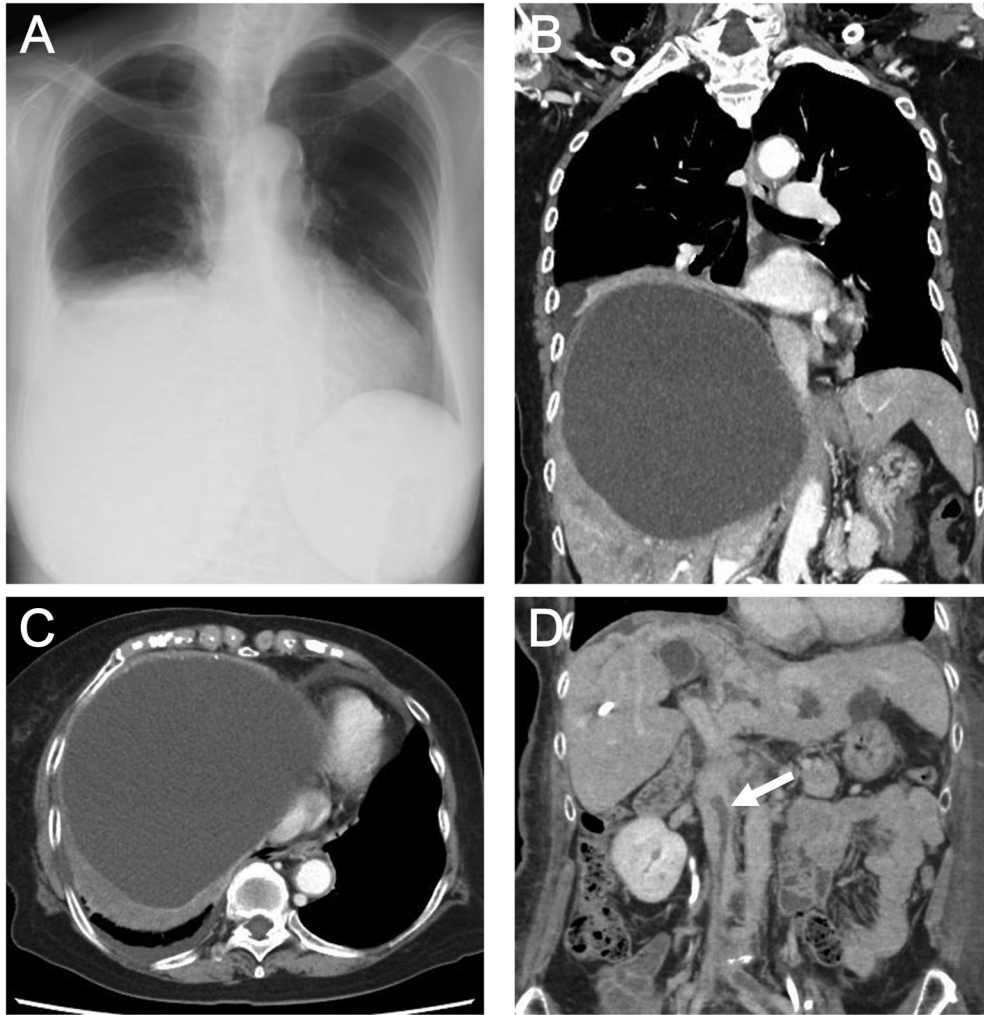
(A) Chest X-ray showed right pleural effusion and elevation of the right diaphragm. (B, C) Chest computed tomography (CT) showed right pleural effusion and a giant liver cyst with a major axis of 18 cm. (D) Contrast CT after drainage of the cyst by percutaneous needle aspiration revealed thrombus (arrow) in the inferior vena cava.
